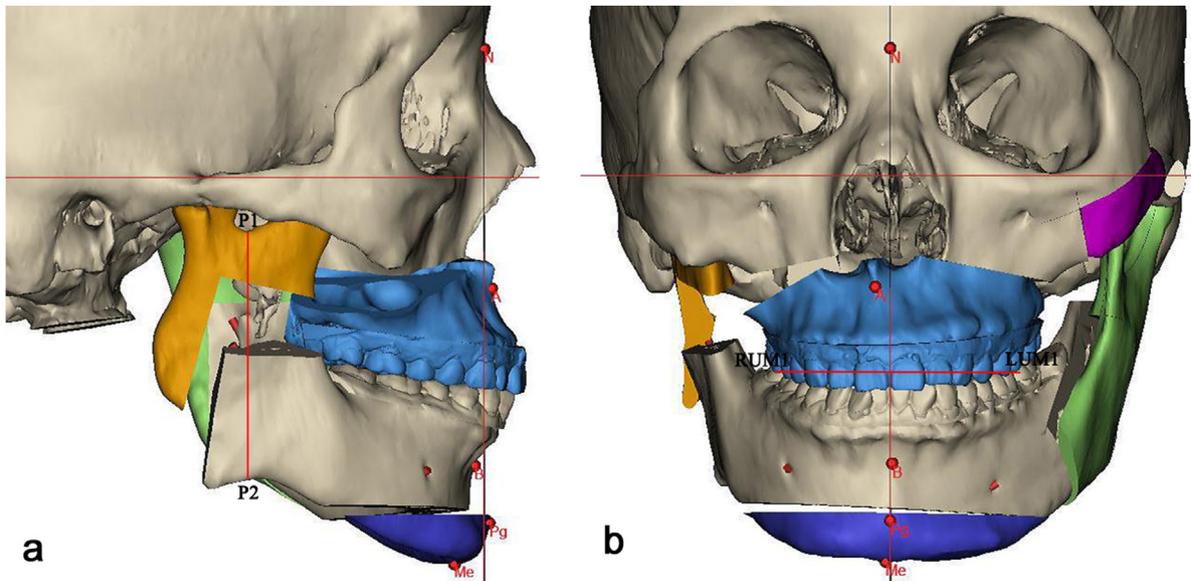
(A) Measurement of affected-side ramus height in a lateral view of a computed tomography (CT) image. The distance between the halfway point of the sigmoid notch (P1) and inferior border of mandible (P2) represents the affected-side ramus height. (B) Measurement of chin deviation and occlusal cant in frontal view of CT image. The distance between the chin point (Me) and the midline represents the chin deviation. The angle formed by the line between bilateral infraorbital margin and another line between the first molars of the upper jaw (LUM1 and RUM1) represents the occlusal cant.
